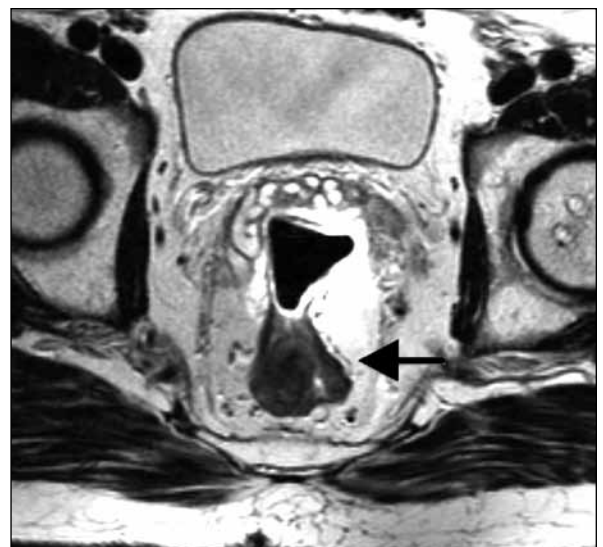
T2-weighted axial image of the rectum with an endorectal coil
